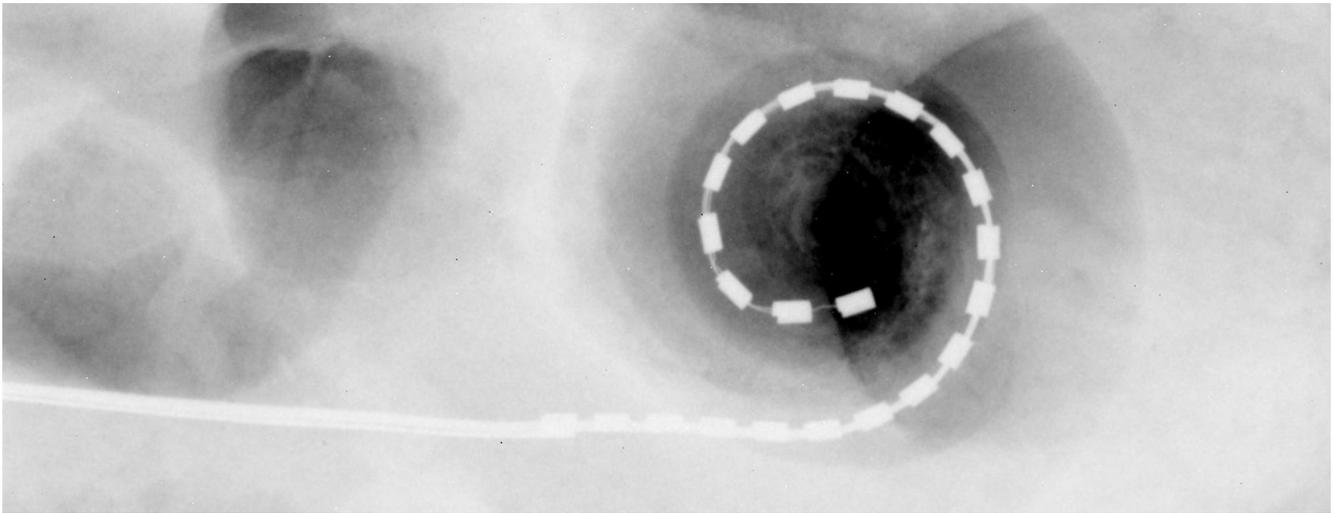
Plain film X-ray showing typical perimodiolar positioning of a Slim Modiolar electrode.
